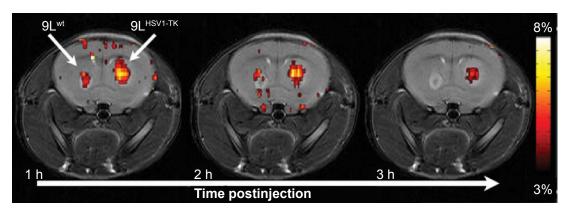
High-resolution MRI images.
